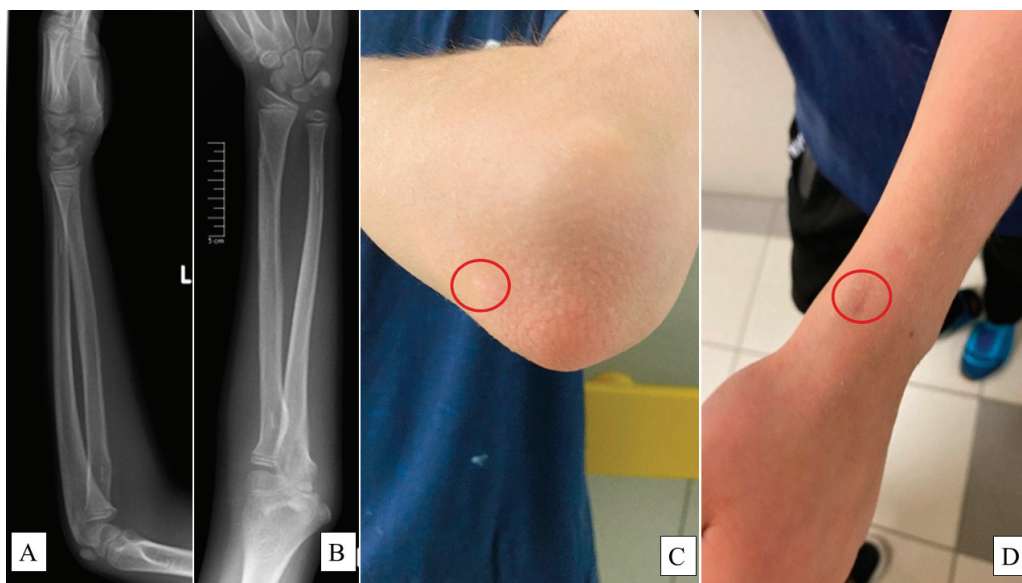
X-rays captured at the one-year follow-up examination of a L pediatric forearm fracture treated with PLGA implants from lateral (A) and AP (B) views showing intact bone growth and development. Surgical scars—highlighted by the red circles—were evaluated via the Vancouver Scar Scale (VSS) on the olecranon ((C), 0 point) and the distal end of the radius ((D), 1 point).
